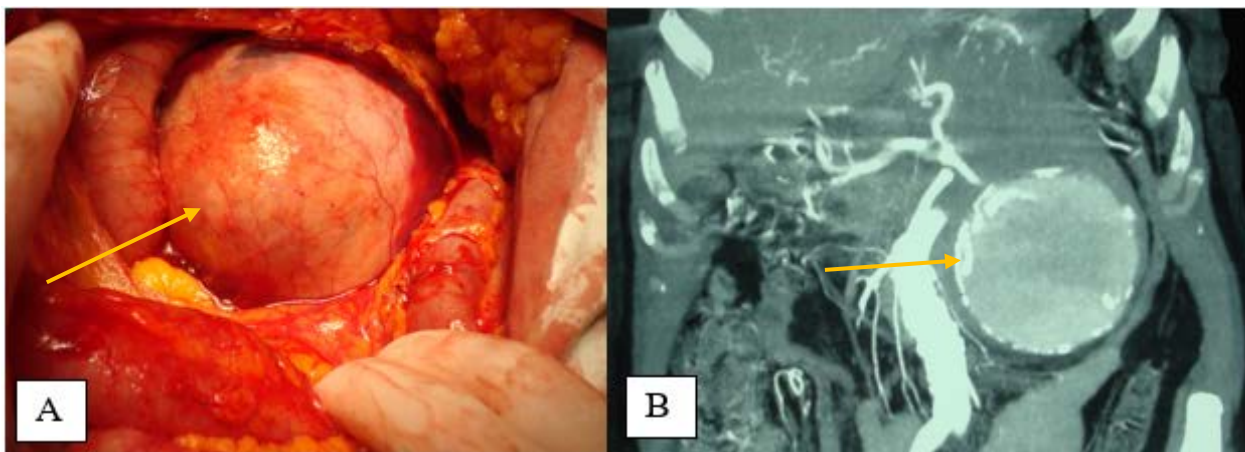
Splenic artery aneurysm: A) intraoperative look and B) multi-detector computed tomography angiography finding.
